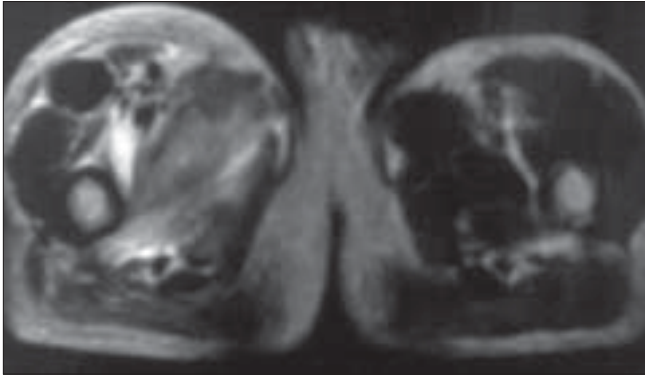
Axial MRI showing increase in the bulk of the muscle on the medial aspect of the right thigh when compared to the left
